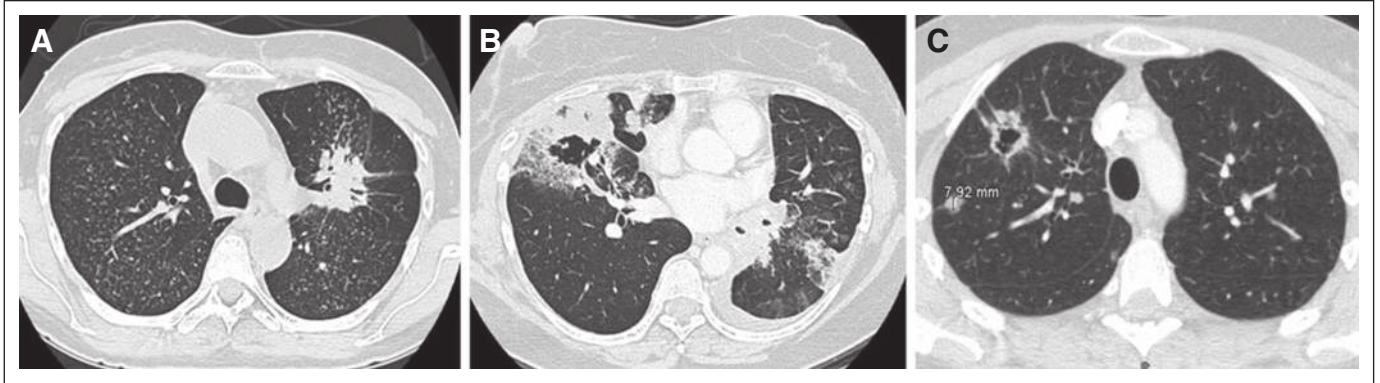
Tumor presentation with a high frequency of disseminated nodules and excavation (computed tomography scan for three patients).
